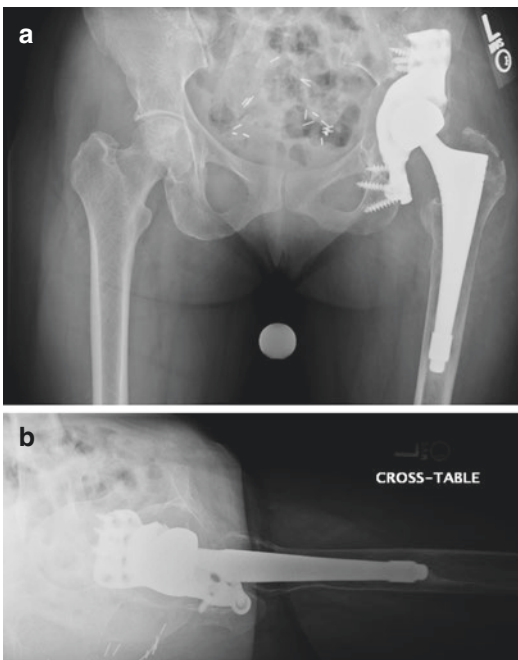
(a, b) Postoperative AP pelvis and cross-table lateral radiographs demonstrating revision THA using a custom biflange implant for acetabular reconstruction, and retention of the original femoral stem
